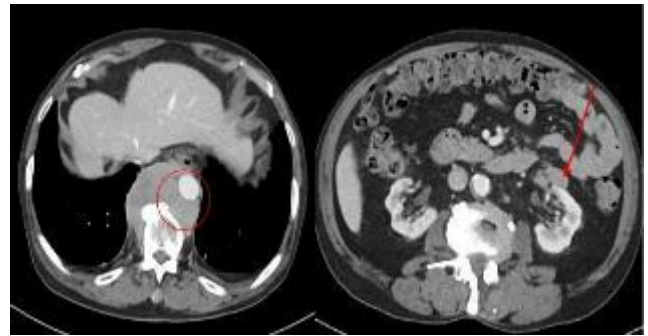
Contrast-enhanced CT showing a retroperitoneal mass (arrow) with posterior mediastinal extension (circle).
